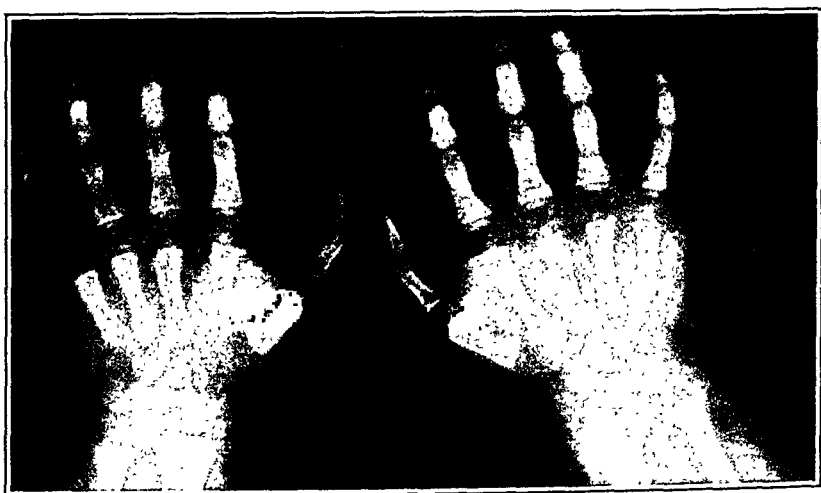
Roentgen ray of hands of CASE II. Aged two years.
